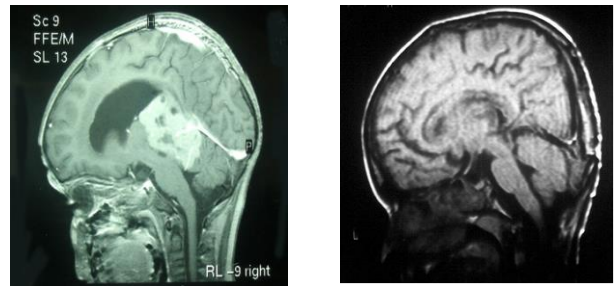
& 4B. Pre-operative sagittal MR image in T1 contrast of pineal region germinoma & post operative sagittal T1 MR after excision and radiotherapy.
